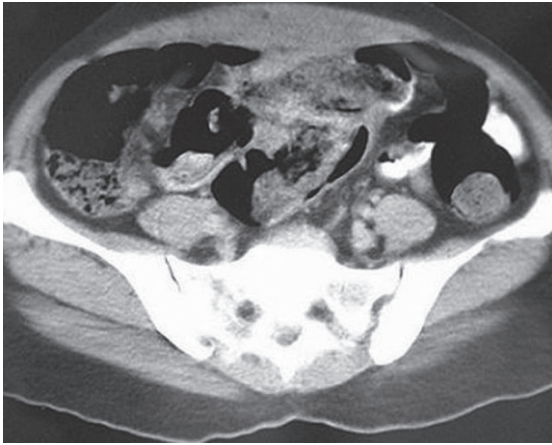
Case 3. Axial CT image shows an irregular mottled soft tissue mass in the central lower abdomen with evidence of adjacent inflammatory thickening of the rectus muscle. It is difficult to tell whether the mass is intra- or extraluminal.
